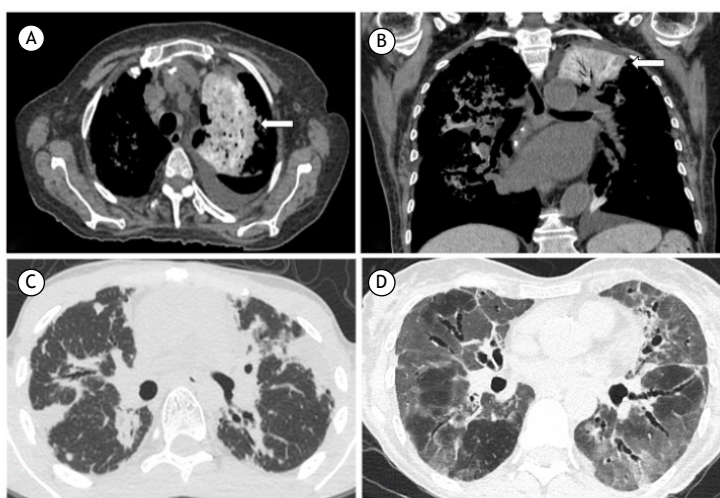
In A and B, axial and coronal CT scans, respectively, showing hyperattenuating lung parenchyma in the upper lobes (arrows) in a 77-year-old female patient with heart failure using amiodarone. In C, CT scan showing bilateral pleural thickening, predominantly in the upper lobes, in a male patient with lymphoma who underwent treatment with cyclophosphamide and developed pleuroparenchymal fibroelastosis. In D, CT scan showing diffuse pulmonary ground-glass opacities in a male patient after use of bleomycin for lymphoma treatment.
